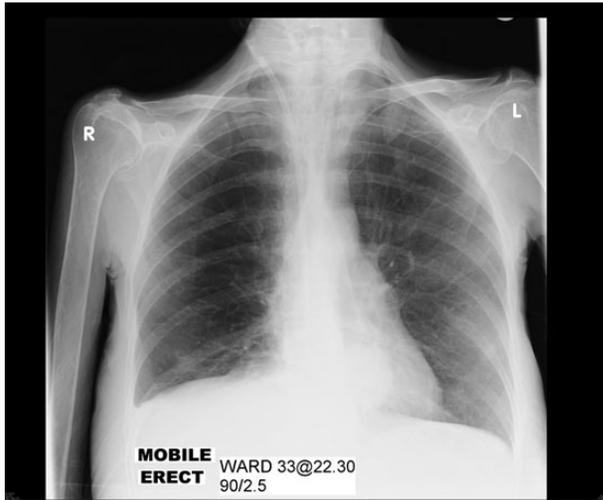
Chest X-ray demonstrating dialysis catheter in place, a normal sized heart and a left retrocardiac mass.
